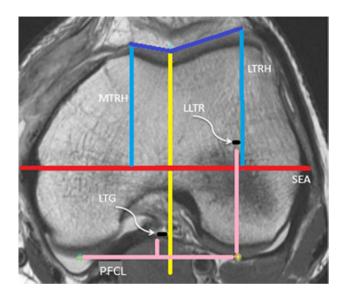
MRI axial slice: femoral axial measurements. LLTR, lateralisation of the lateral trochlear ridge; LTG, lateralisation of the trochlear groove; LTRH, lateral trochlear ridge height; MTRH, medial trochlear ridge height; PFCL, posterior femoral condylar line; SEA, surgical epicondylar axis
